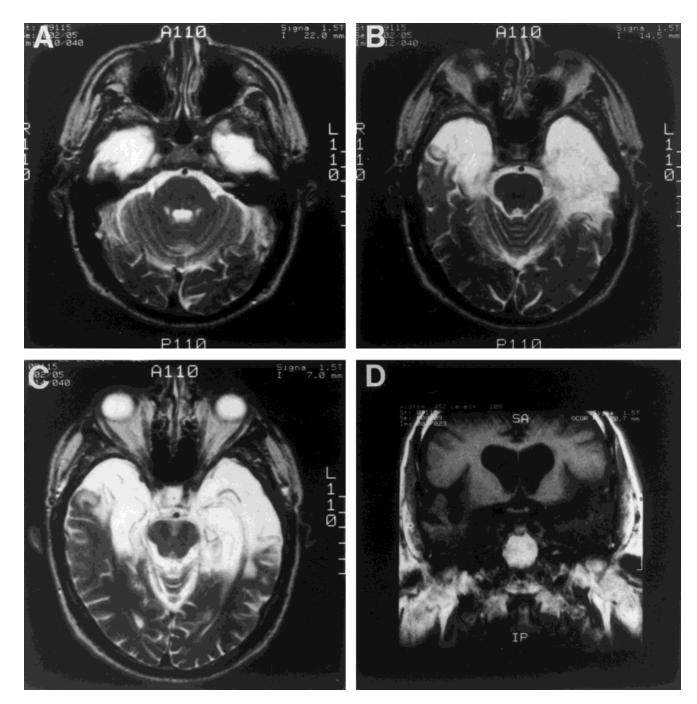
Magnetic resonance images showing the extent of bilateral temporal lobe damage in patient G.T. A–D are arranged as in Figure 1. The damage extends through the anterior 7 cm of the left temporal lobe and the anterior 5 cm of the right temporal lobe. The damage bilaterally includes the amygdala, the hippocampal region, and the entorhinal, perirhinal, and parahippocampal cortices. Lateral cortical regions (fusiform gyrus, and inferior, middle, and superior temporal gyri) are also damaged bilaterally at the level of the temporal
